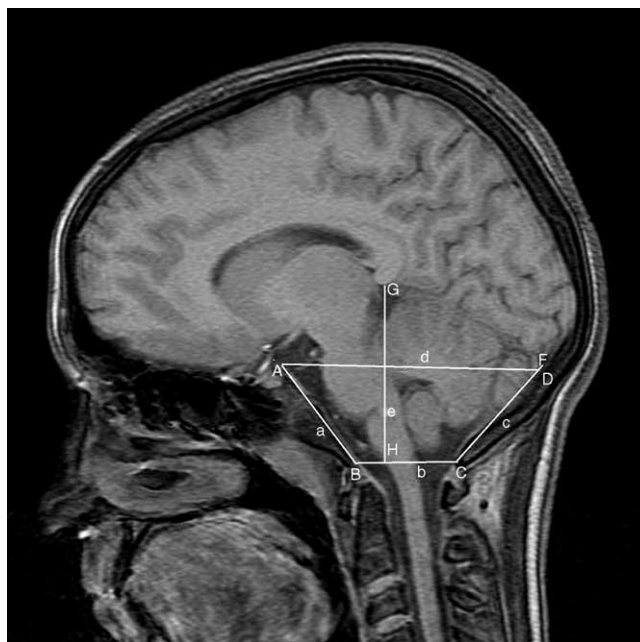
Demonstration of the measurements of PCF made on T1-weighted mid-sagittal MRI of healthy subjects. The length of the clivus (a) was measured along a line drawn from the top of the dorsum sella (A) to the basion (B). The anteroposterior diameter of the foramen magnum (b) was measured from the basion (B) to the opisthion (C). The length of the supraocciput (c) was measured along a line drawn from the opisthion (C) to the center of the internal occipital protuberance (D). The anteroposterior diameter of the PCF (d) was measured along a line parallel to the plane of the foramen magnum, from the top of the dorsum sella (A) to a point 1 cm above the internal occipital protuberance (F). The height of PCF (e) was measured with a line drawn from the inferior aspect of the splenium (G) perpendicular to the plane of the foramen magnum (H).
